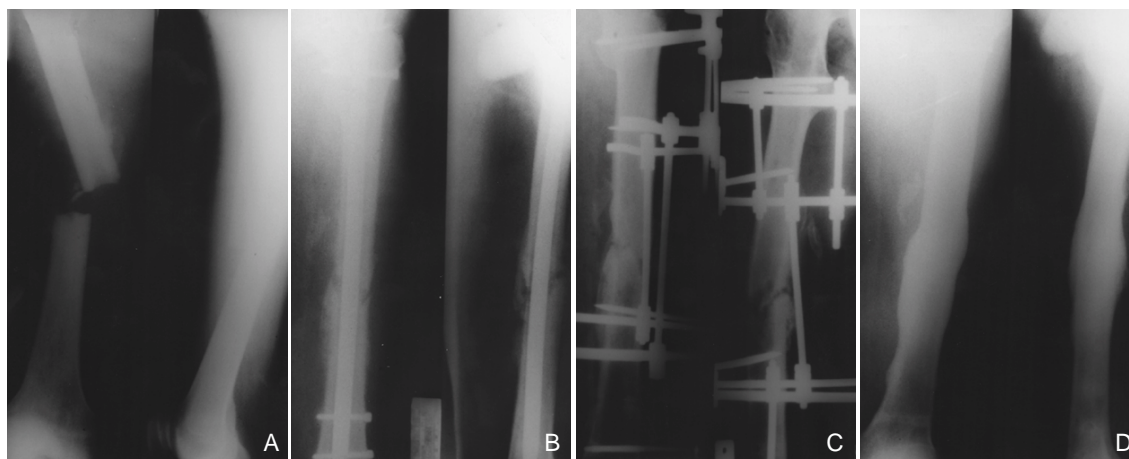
The preoperative radiograph of 41-year-old man shows transverse femoral shaft fracture.
